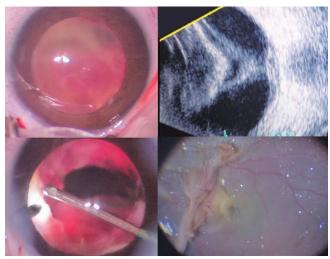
This patient with posterior PFV presented with retrolental and vitreous hemorrhage, mimicking a closed-funnel RD on B-scan ultrasonography. A limbal lensectomy and vitrectomy, followed by layer-by-layer removal of dense hemorrhagic membranes, uncovered a hyaloid stalk extending from the optic nerve head and forming retinal folds in all directions. The surgery resulted in an attached retina including the macula except from the narrow retinal folds in the nasal area.
